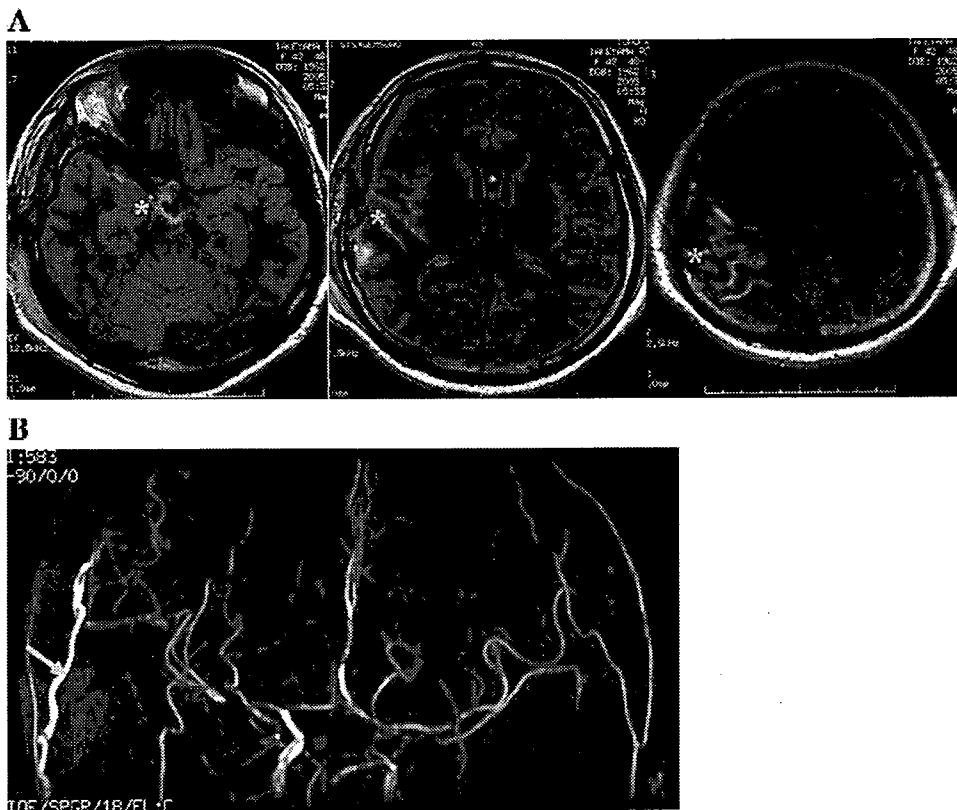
Case 8. FLAIR by MRI 2 days after surgery demonstrating subarachnoid hemorrhage around the site of anastomosis, extending to the ipsilateral sylvian cistern and the basal cistern (asterisks in A). Postoperative MRA showing the apparently patent bypass as a higher intensity signal than the opposite side STA (arrow in B). Significant visualization of the branches of MCA around the site of anastomosis was also evident compared with the preoperative state.
